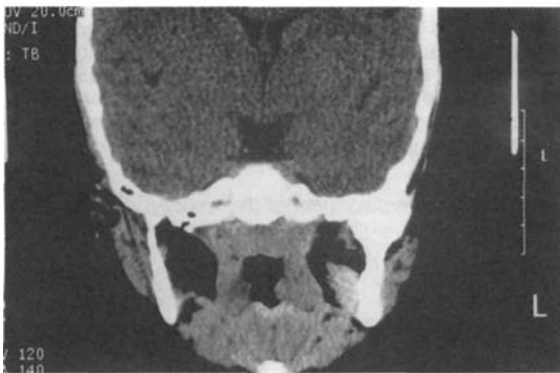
Coronal cut of CT scan showing a deformed, mushroom shaped left condyle.
